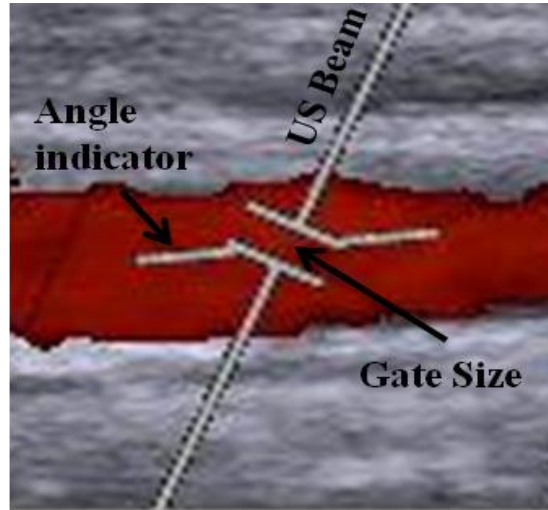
Pulsed Wave Doppler.
